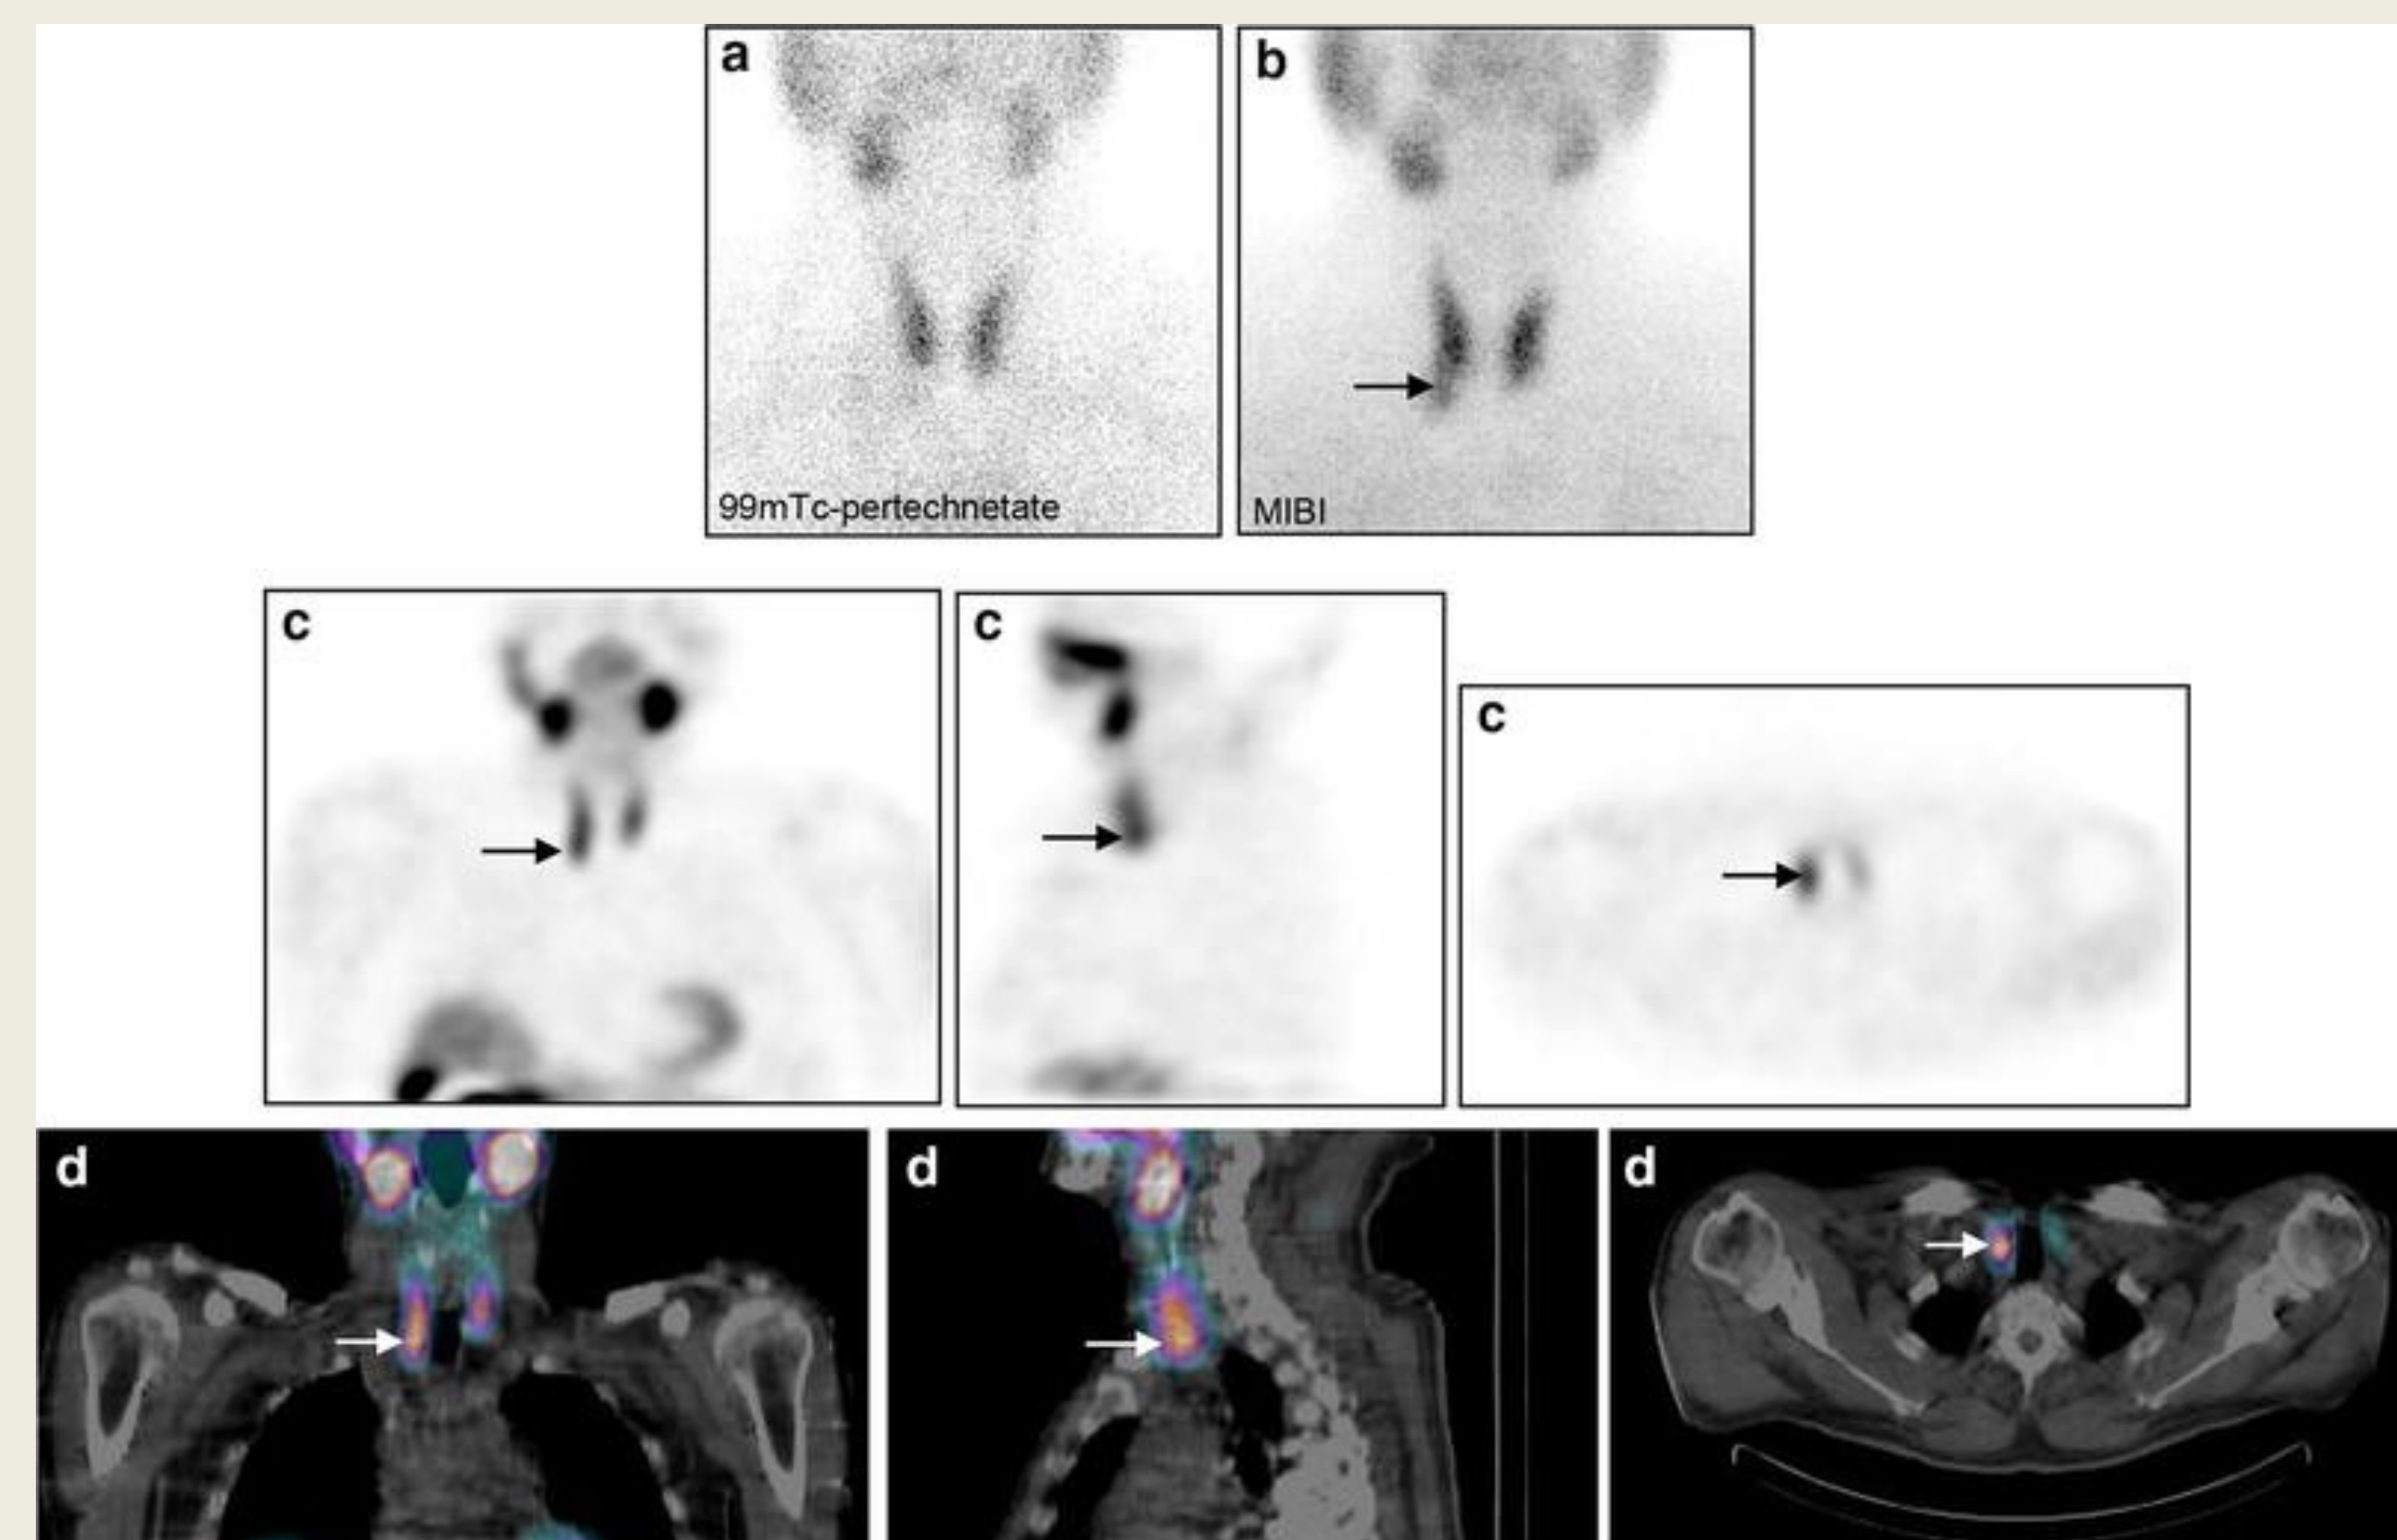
SPECT/CT in Primary Hyperparathyroidism
